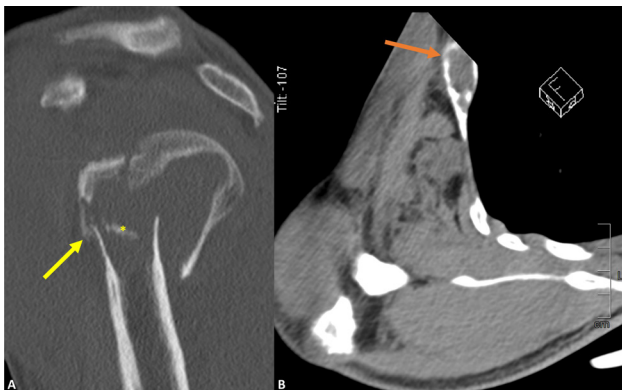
Non-enhanced CT of the right shoulder. Sagittal CT reconstruction in bone window (A) and axial CT image in soft-tissue window (B) demonstrate a fractured central lytic lesion in the proximal humerus, with a narrow zone of transition and no periosteal reaction (yellow arrow), favouring a benign process, as well as a lytic lesion in a rib (orange arrow). A fallen fragment is present within the lesion (yellow asterisk), a sign often observed in, but not specific to, simple bone cysts.
